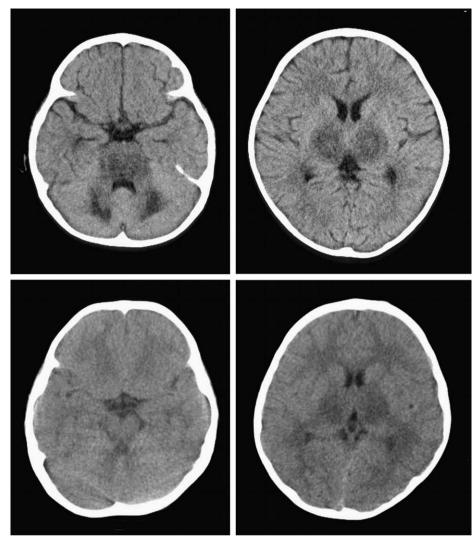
CT findings. Upper: 21-month-old boy with brainstem lesions. Low density areas are observed in the upper brain stem tegmentum and cerebellar medulla as well as bilateral thalami. Lower: 35-month-old boy without brainstem lesions. Low density areas are present in bilateral thalami, whereas no low density areas are recognized in the brainstem.
